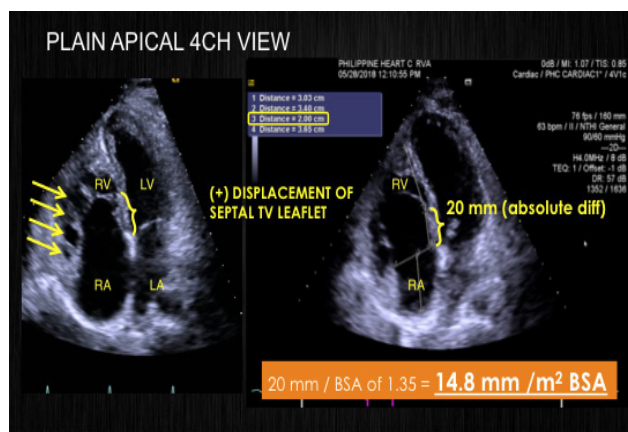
An apical 4 chamber view 2 dimensional echocardiogram showing apical displacement of the septal tricuspid valve leaflet by 14.8mm/m²
